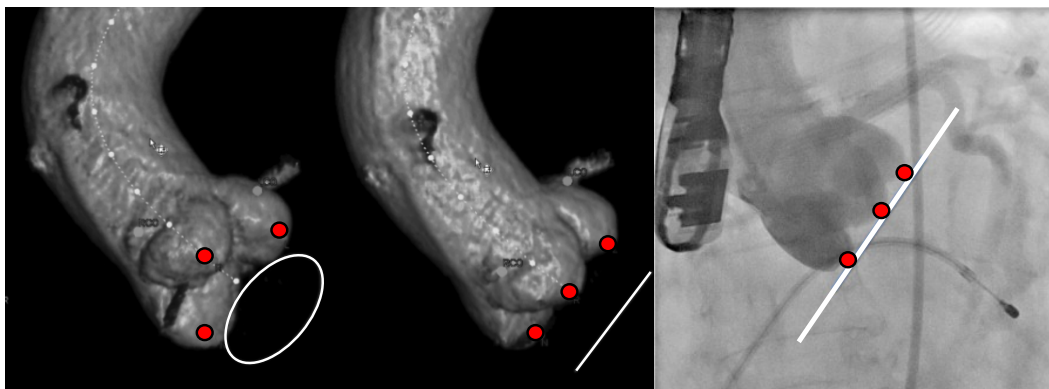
Left (Image modified from [18]): CT volume renderings of an aorta with different virtual XRF projection views. The view in the middle aligns the inferior portions of all 3 coronary cusps, indicating that the annulus is parallel to the source-detector axis, as opposed to the view on the left. Right (Image modified from [19]): An example XRF image during an aortogram, where all three cusps are aligned and therefore at the optimal XRF projection angle.
